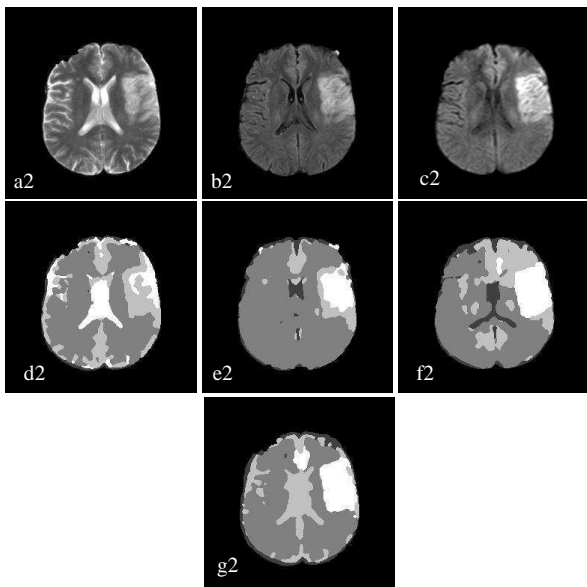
MRI sequences with a stroke lesion in the middle cerebral artery territory (MCA)
